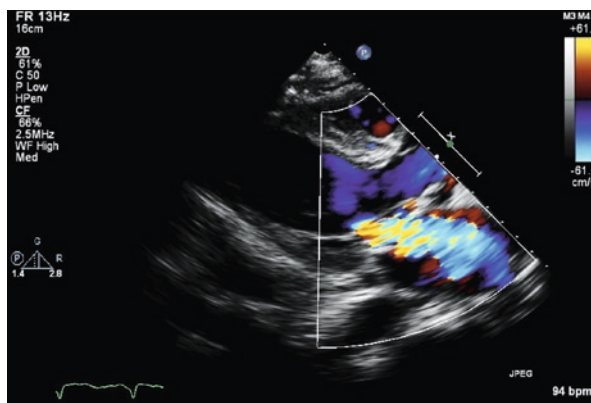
Parasternal long axis – color flow image. Color flow Doppler imaging is used to assess the valves for regurgitation. Pictured here is a systolic still frame demonstrating regurgitation of blood flow back through the mitral valve into the left atrium
